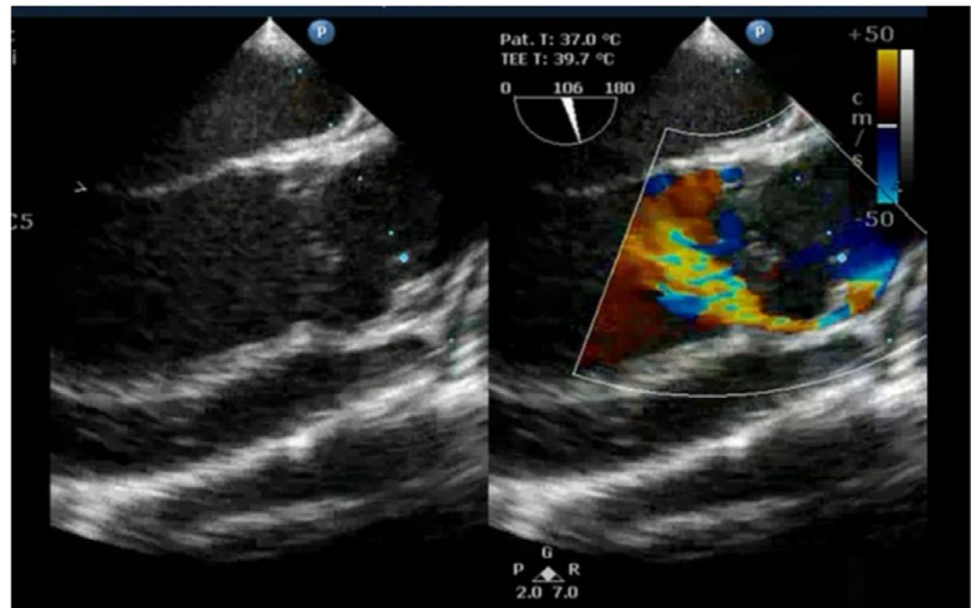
Transoesophageal echocardiography showing complete length of aorto-left ventricular tunnel with diastolic runoff from aorta to the ventricle.
